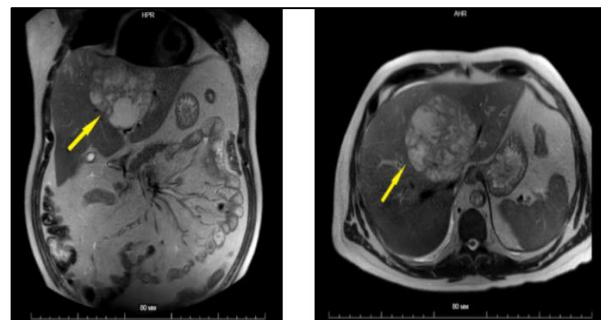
Abdominal MRI, multichambered mass with indistinct contours is detected in the right lobe of the liver (yellow arrow).
